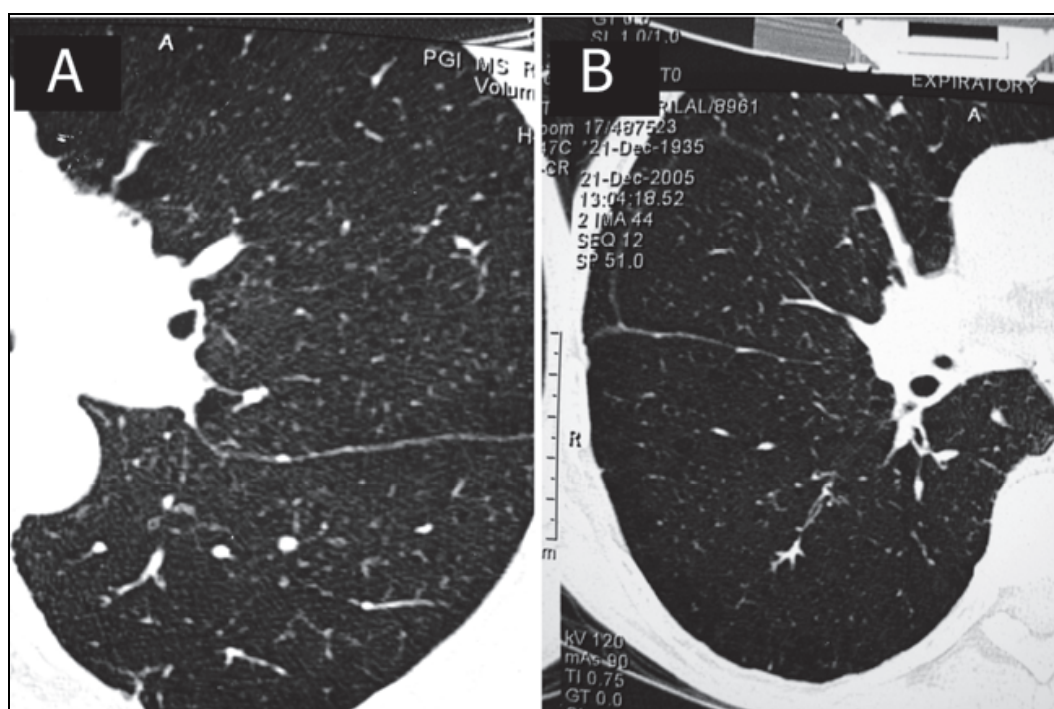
(A-B): Panacinar emphysema: HRCT scans showing diffuse low attenuation lung parenchyma – typical of panacinar emphysema
